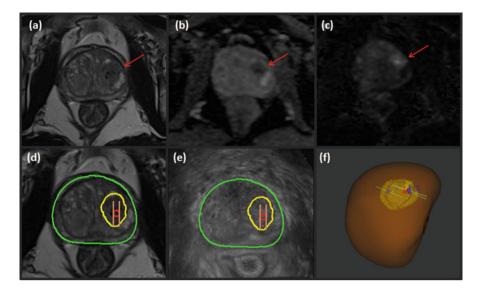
Suspicious lesion visualized as (a) hypointense area on T2W image, (b) restricted diffusion with low ADC, and (c) high signal on diffusion-weighted image. Targeted biopsy workflow showing segmented prostate and lesion on (d) T2-weighted MRI, (e) transrectal ultrasound, and (f) 3D reconstruction of prostate and suspicious region
